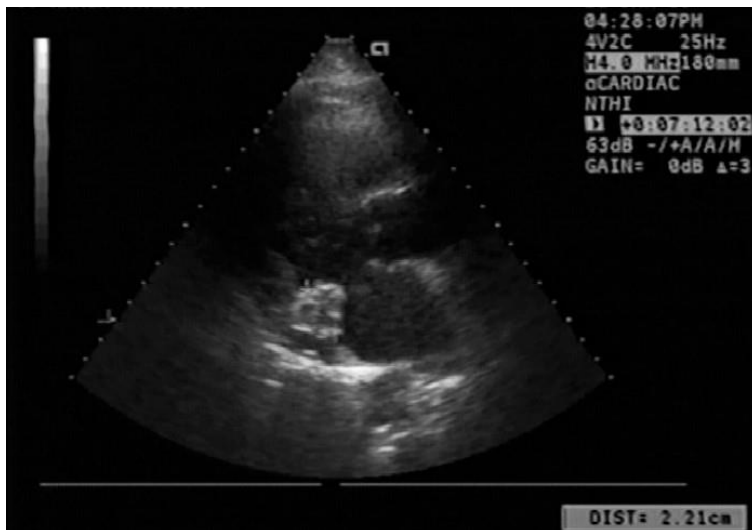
Echocardiographic image. Parasternal long-axis view.
